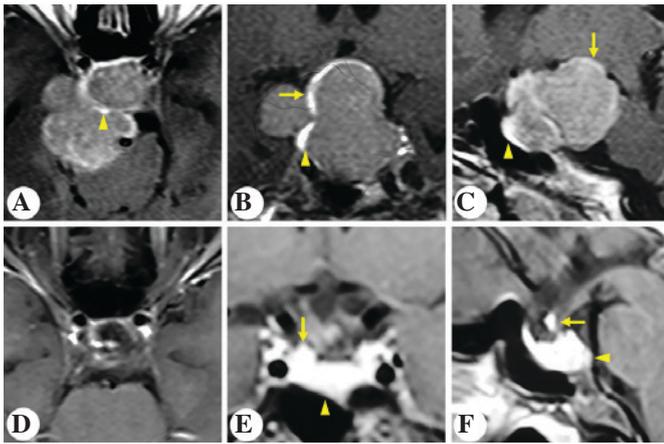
Patient 5. Representative post contrast T1-weighted images. Preoperative (A) horizontal, (B) coronal and (C) sagittal and postoperative (D) horizontal, (E) coronal and (F) sagittal magnetic resonance imaging of the sellar region. Arrows indicate the pituitary stalk. Arrowheads indicate the pituitary gland.
